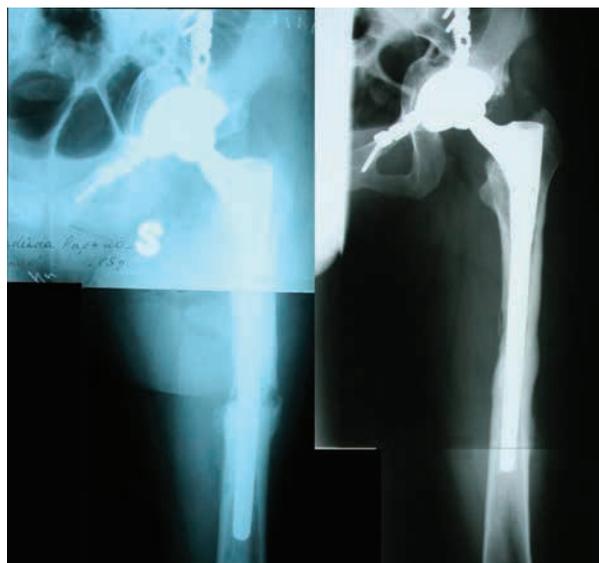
Plain radiographs three months and one year after hip replacement.
